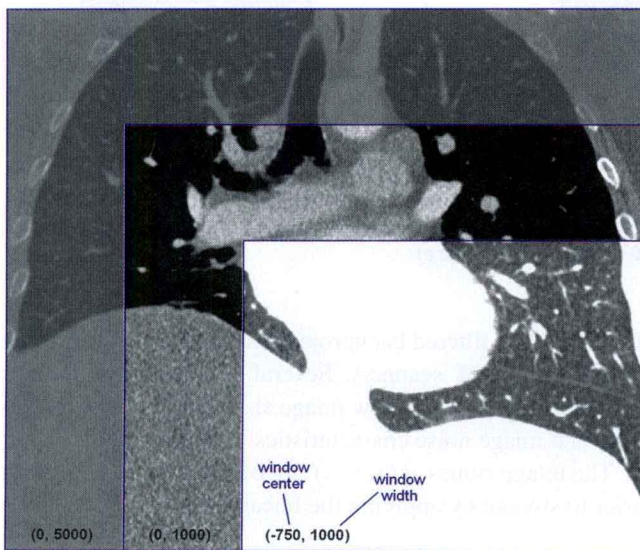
CT image of the thorax displayed with three different window settings
